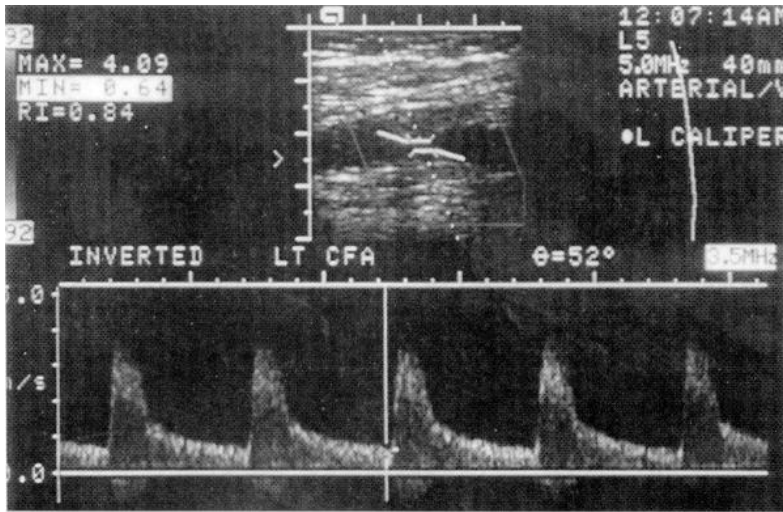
Duplex ultrasound of the common femoral artery. The *upper* image shows a gray-scale image of the artery in which plaque is present and encroaching on the lumen. The *lower* image is a recording of the pulsed Doppler velocity sampled from the common femoral artery. The peak velocity of 350 cm/sec is elevated. These features are consistent with significant stenosis.
